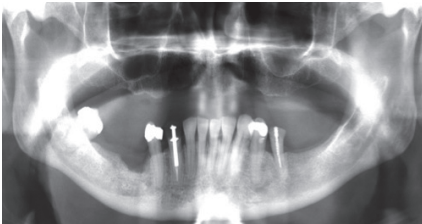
Panoramic radiograph: Stage 2 MRONJ: lysis in the right alveolar process in the region of the 45. Sclerosis is visible in the right mandibular body (the alveolar nerve canal is more lucent and the bone marrow is more opaque in comparison to the left side).
